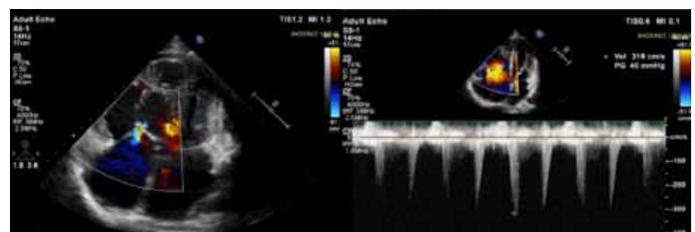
Mild tricuspid regurgitation and measurement of PAP as 65 mmHg in echocardiography performed at the 3rd month after discharge.
